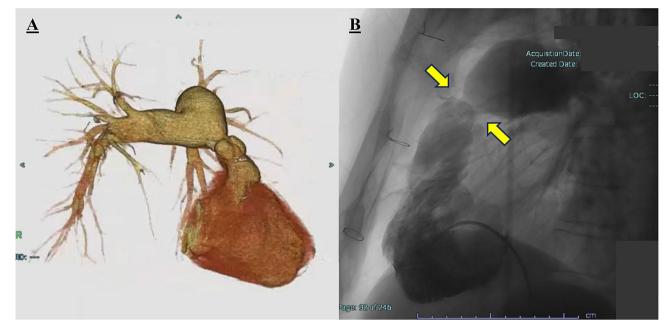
(A) Three-dimensional computed tomography scan of the right ventricular outflow tract and pulmonary artery. (B) Right ventricular angiography, pulmonary stenosis (yellow arrow). The pressure gradient was 60mmHg
